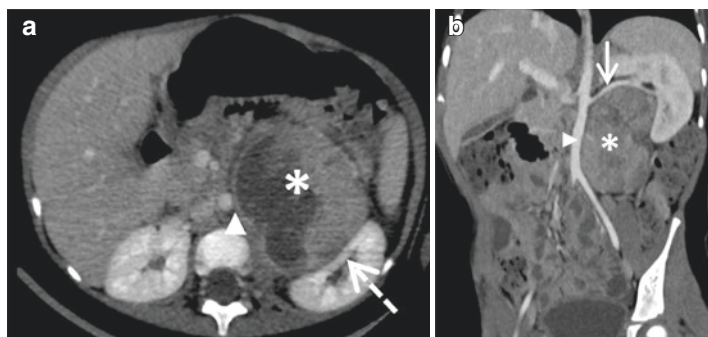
A 3-year-old boy with localized left extra-adrenal retroperitoneal neuroblastoma (asterisks). Contrast-enhanced CT scan with transverse view (a) and coronal MIP reconstruction (b) show the displacement of the right kidney without infiltration (dotted arrow) (not IDRF), a contact with the aorta (arrowheads) without encasement (not IDRF), and a contact with the renal artery (arrow) (IDRF)
